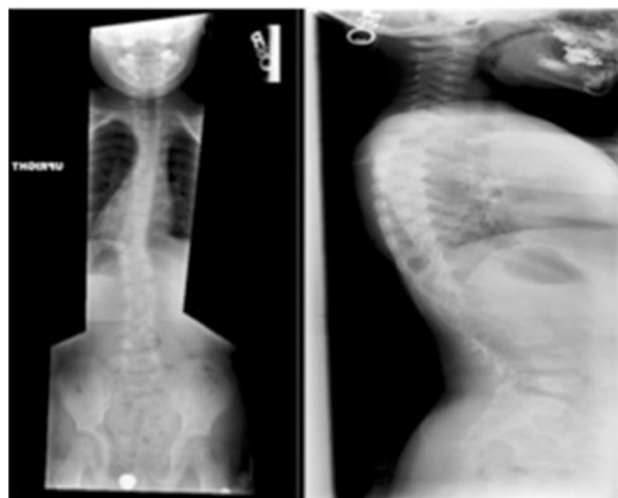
AP and lateral plain film X-ray of twin A on presentation demonstrating left T10 hemivertebra, left thoracic scoliosis from T9 to T11, and block vertebra with fusion between L1 and L3
